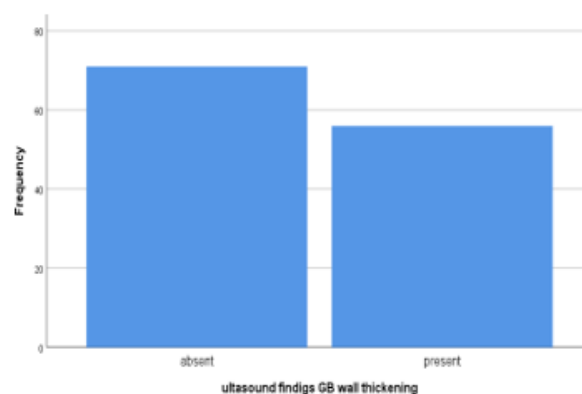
Ultrasound findings related to gallbladder (GB) wall thickening
